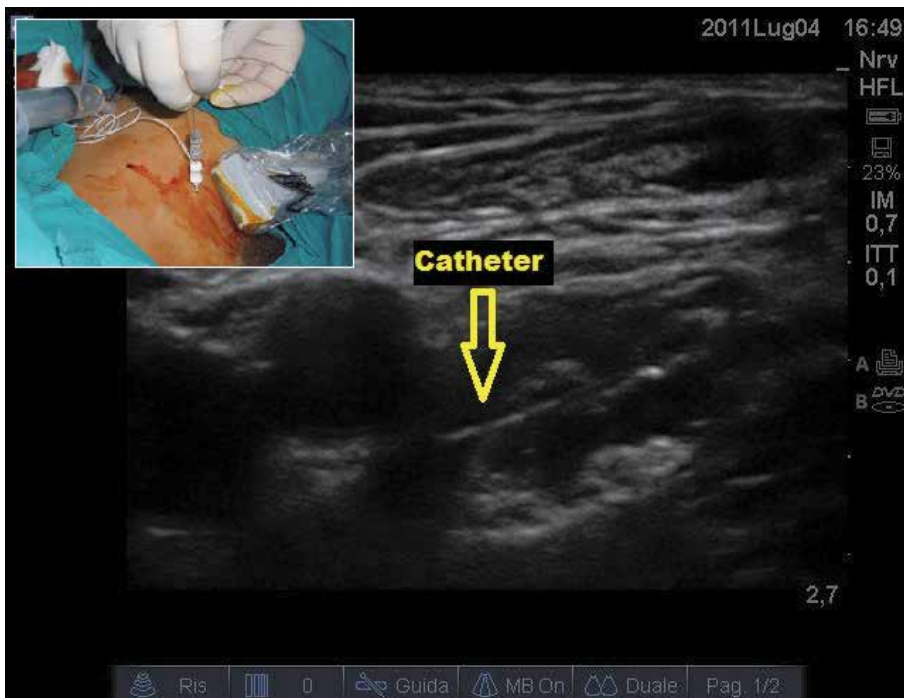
Ultrasound guided femoral nerve block: catheter insertion
